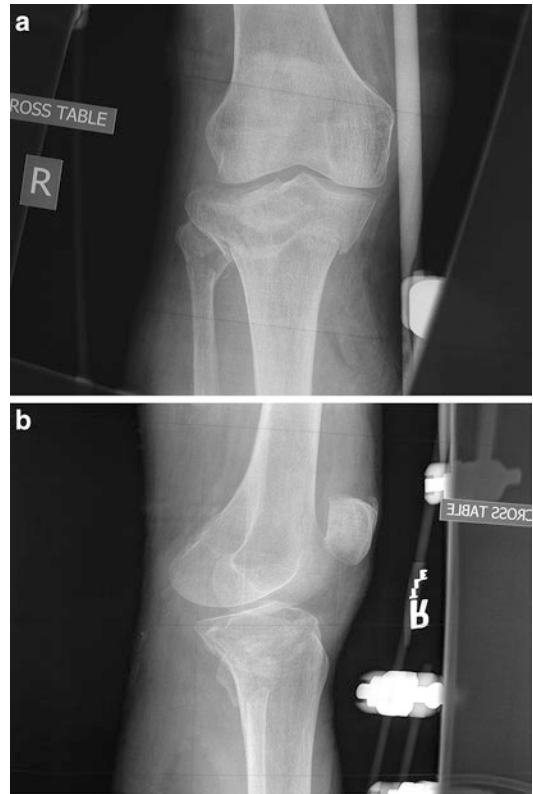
(a) AP radiograph knee—postexternal fixation. (b) Lateral radiograph knee—postexternal fixation
